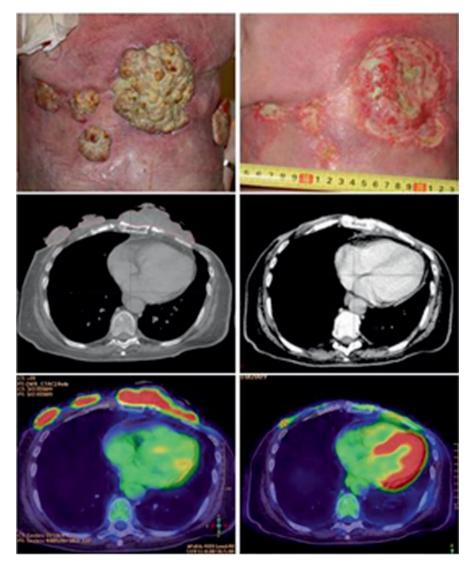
Patient treated with electrochemotherapy against extensive chest wall recurrence. Sixtyfour-year-old woman with locoregional recurrence of bilateral receptor negative, HER2-negative breast cancer. Previous treatments over a period of 5 years included radiotherapy 48 Gy in 24 fractions on both sides and reirradiation with 30 Gy in 10 fractions on the left side, systemic therapy (cyclophosphamide, epirubicin, fluorouracil, docetaxel, gemcitabine, vinorelbine, and capecitabine). Despite all these treatments, there was continuous progression of the cutaneous lesions. The column on the left shows image of lesions, CT scan, and PET/CT scan before treatment scan; column on the right shows image of lesion, CT scan, and PET/CT scan after two sessions with electrochemotherapy. (HER2 human epidermal growth factor receptor 2, CT computerized tomography, PET positron emission tomography). From Matthiessen et al. (2012)
